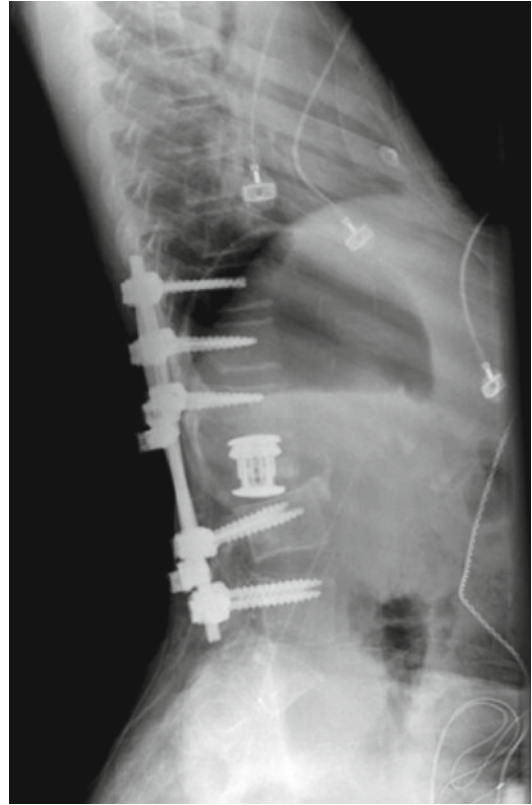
Shown here is a postoperative radiograph of a corpectomy with interbody cage. Note that supplemental posterior instrumentation with pedicle screws and bilateral rod fixation
